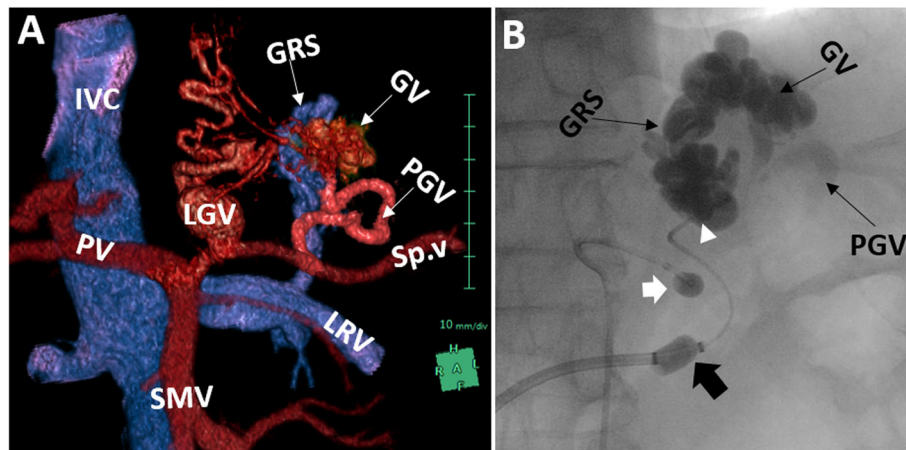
Conventional BRTO technique. a Color-coded volume rendering image obtained from pre-BRTO CE-CT portal phase images shows gastric varices (GV) supplied mainly from posterior gastric vein (PGV) and small branch from left gastric vein (LGV) and drained by gastroduodenal shunt (GRS). b Fluoroscopic image obtained at the end of BRTO shows 9F Balloon occlusion guiding catheter positioned at the base of the GRS (black solid arrow) through which a 5F balloon catheter was advanced till the mid part of the GRS (white arrowhead). The distal and mid parts of the GRS, GV, and part of the PGV were totally opacified with EOI. Noted splenic artery balloon occlusion catheter (white solid arrow)
